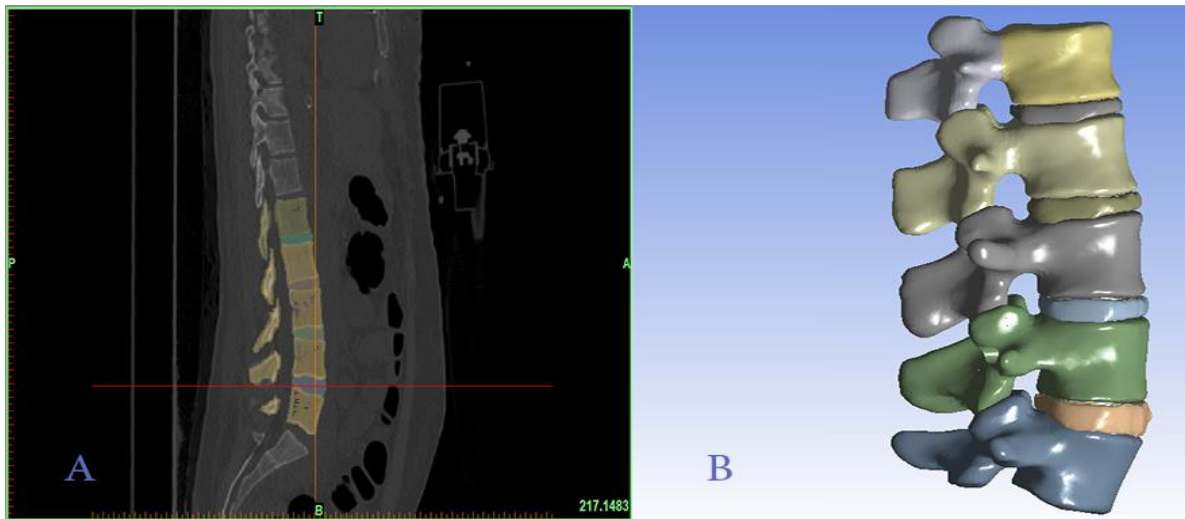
Constitution of CAD model of lumbar spine. A) Sagittal section of CT images; B) The 3D model of the lumbar spine including nucleus pulposus and annulus ground substance
